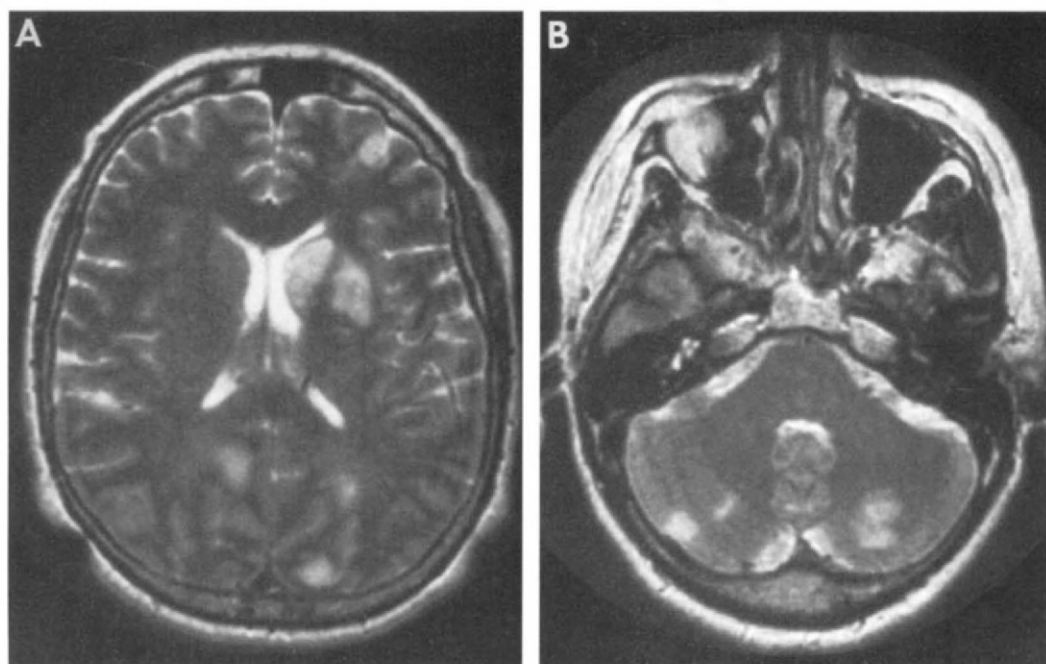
Repeat magnetic resonance image (MRI) of the head performed 3 days after the first MRI showed significant progression with multiple new areas of T₂ signal abnormality in both cerebral hemispheres (A) and both occipital lobes (B).
